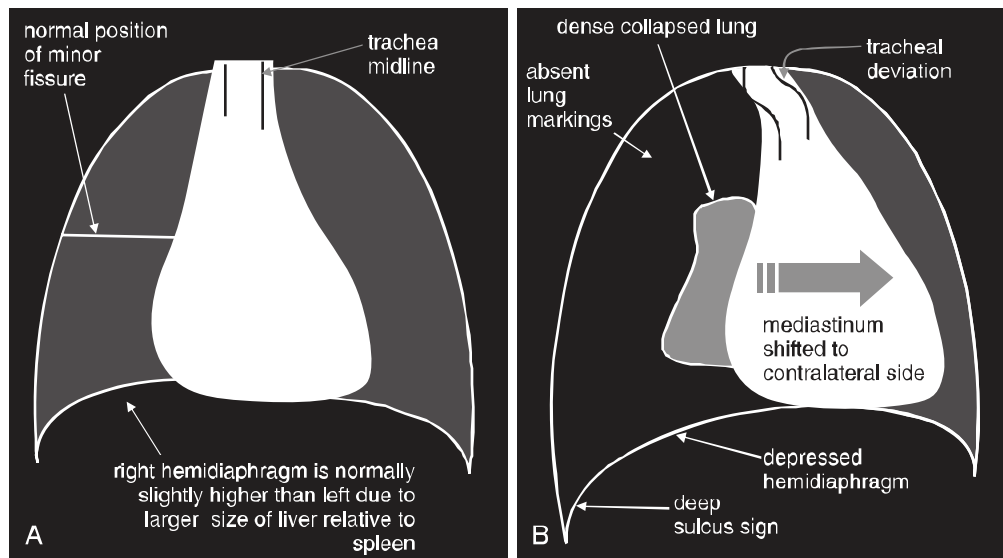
Changes in pressure and volume on chest x-ray. (A) Lungs and mediastinum under normal conditions of pressure and volume. The heart and airway are near the midline. The minor fissure is in normal position. The right diaphragm is usually slightly higher than the left, because of the larger size of the liver relative to the spleen. (B) Increased pressure results in mediastinal shift and tracheal deviation to the opposite side. In the case of a right-sided tension pneumothorax, the right hemidiaphragm may be displaced in a caudad direction and may be lower than the left hemidiaphragm—the reverse of their normal positions. In addition, in any tension pneumothorax the costophrenic angle may be extremely deep on the abnormal side owing to a hyperinflated pleural space—the deep sulcus sign. (From Broder JS. *Diagnostic Imaging for the Emergency Physician*. Philadelphia, PA: Saunders; 2011.)
